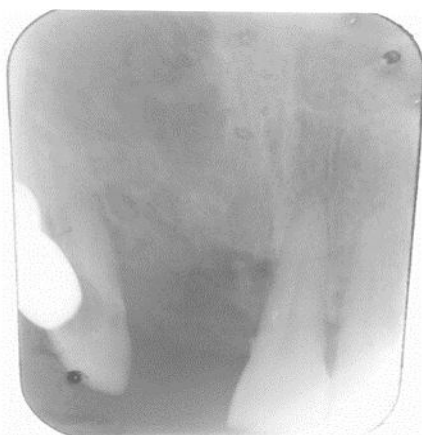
Intra-oral Periapical radiograph showing no bony changes
